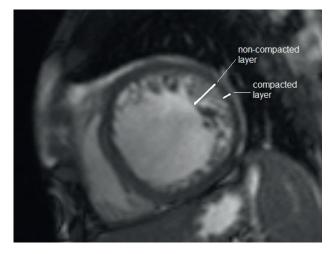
Patient 24 y.o. Cardiac MRI. Short axis view.
